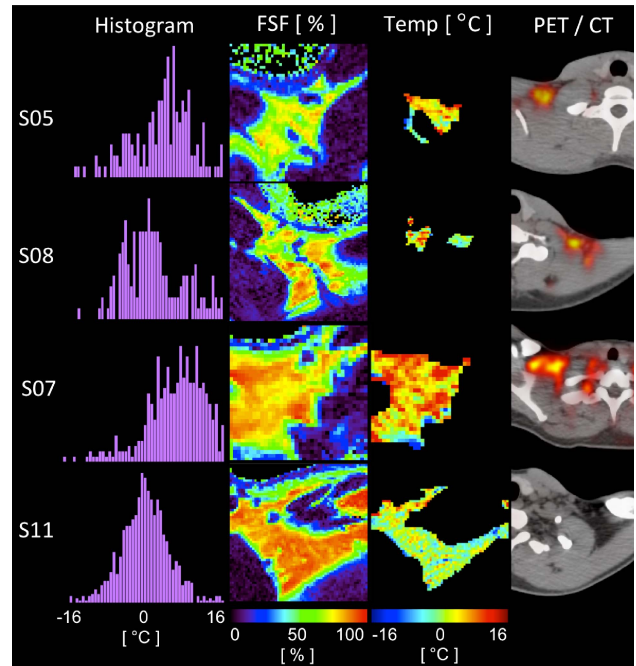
Axial slices from high-resolution mFFE cold-activation scans showing: column 1: histograms of temperature, column 2: FSF maps, column 3: masked temperature maps, column 4: PET activation on CT.
